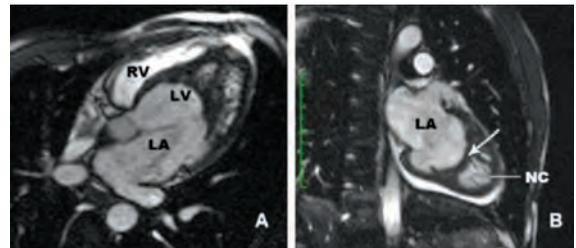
Magnetic resonance imaging. A. Transverse plane B. Sagittal plane. LV: Left ventricle, LA: Left atrium, RV: Right ventricle, White arrow: Anomalous muscle shelf, NC: Non-compacted area.
